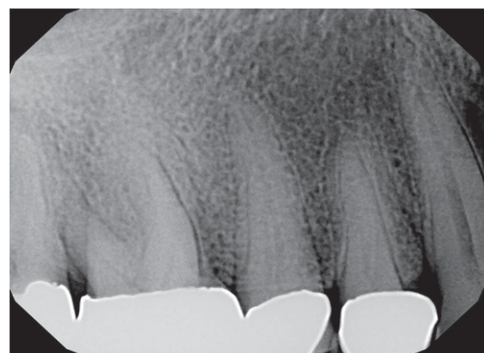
Periapical radiograph of infected maxillary right first molar. Endodontic evaluation indicated that the tooth was not salvageable.
